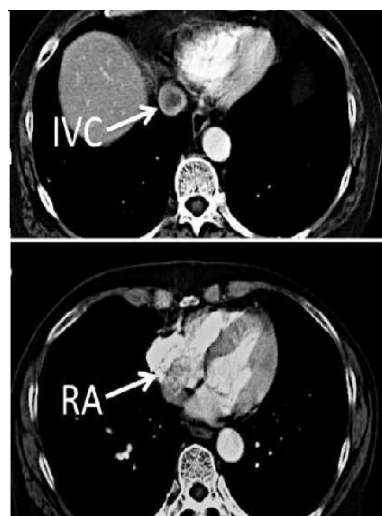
CT scan both shows the mass.
